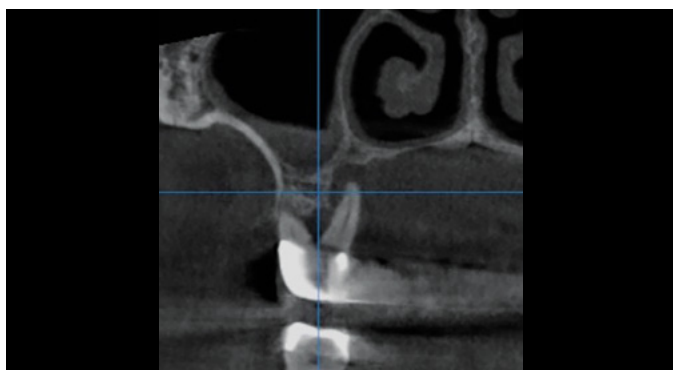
CBCT cross-section no 16
